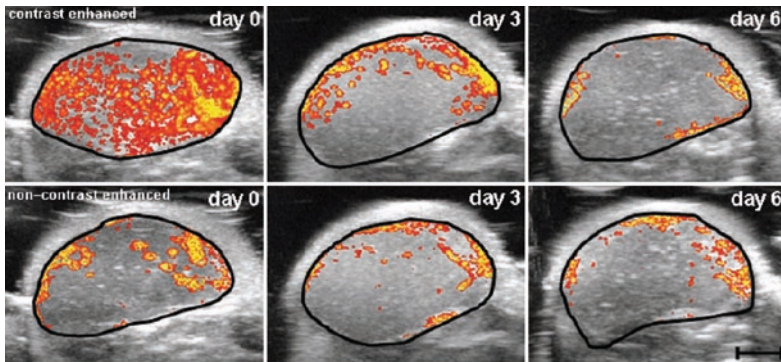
Contrast-enhanced and non-contrast-enhanced most intensity projections of A431 squamous cell carcinoma xenografts during treatment with a multispecific tyrosine kinase inhibitor. Already after 3 days, a strong collapse of vascularization in the tumor center can be observed by contrast-enhanced imaging, indicating strong and early degradation of small immature vessels. As expectable larger and more mature vessels predominantly located at the tumor periphery and displayed by non-contrast-enhanced Doppler imaging, are less responsive. Particularly between day 3 and 6, further decrease in vascularization is only visible on the contrast enhanced image. Bar, 1 mm (Figure taken from [15])
